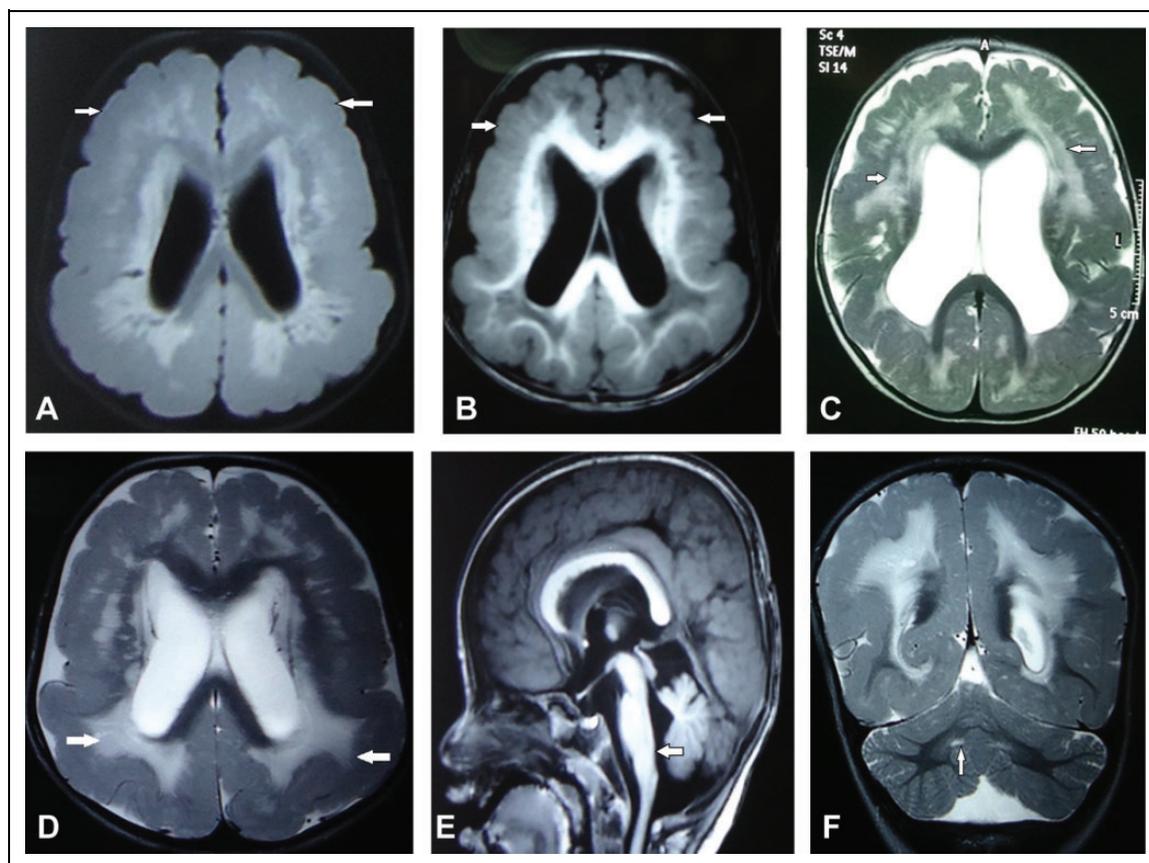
Representative brain magnetic resonance images (MRIs) of patients with *GPR56*-associated polymicrogyria. (A),(B) Showing PMG; (C),(D) Showing white matter changes; (E) Brainstem hypoplasia; and (F) Cerebellar cyst.
